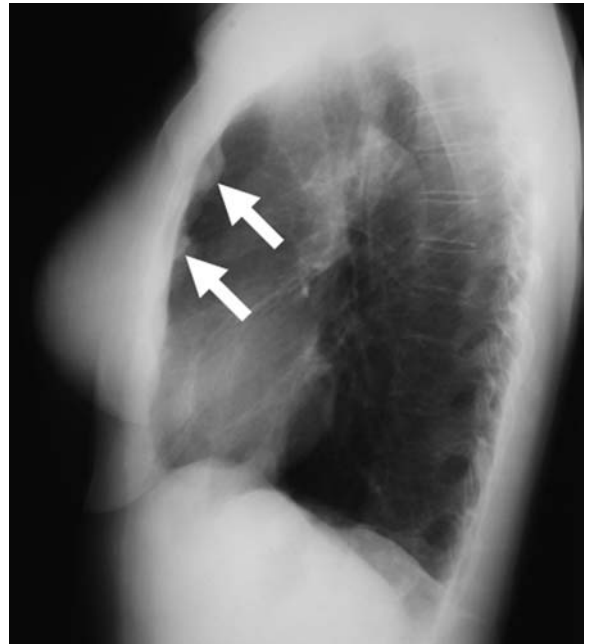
Lateral chest radiograph (a) and computed tomography scan of the chest (b) show smooth pleural thickening (arrows) in a patient with left renal carcinoma and homolateral pleural metastasis
